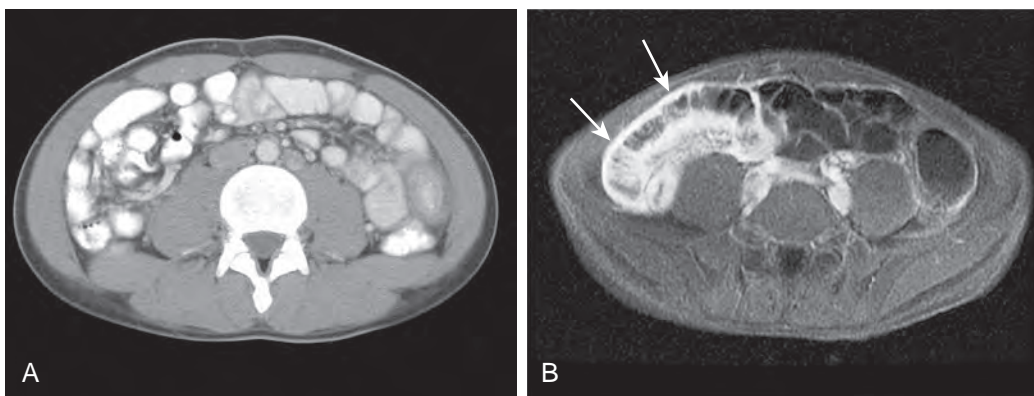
Infectious ileitis. A. Helical CT scan through the middle abdomen is unremarkable. B. GE fat-suppressed, SGE MR image with oral contrast material shows abnormally thickened and enhancing ileum (arrows) in the right side of the abdomen. MRI, the patient was treated for an infectious ileitis, with good clinical response.
